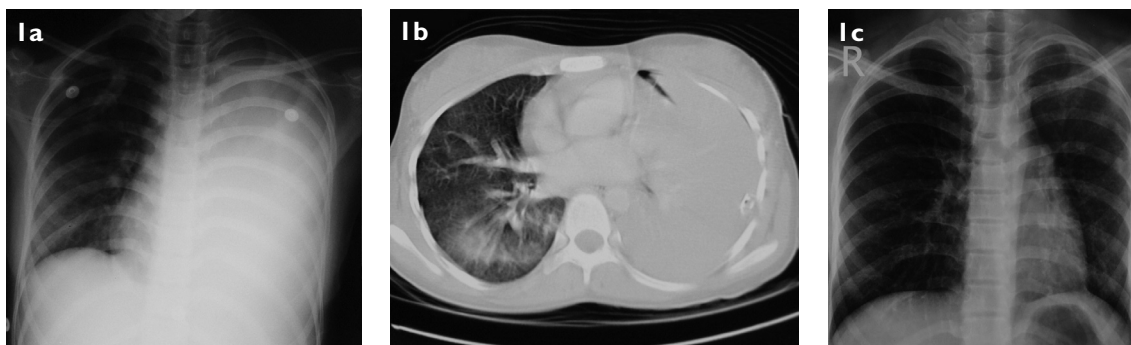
(a) Chest roentgenogram shows left opaque hemithorax with contralateral mediastinal shift. (b) Contrast-enhanced CT of the thorax (lung window) shows complete consolidation of the left lung, with the left intercostal tube *in situ* and right basal infiltrates. (c) Chest roentgenogram one month after steroid treatment shows near complete resolution.
